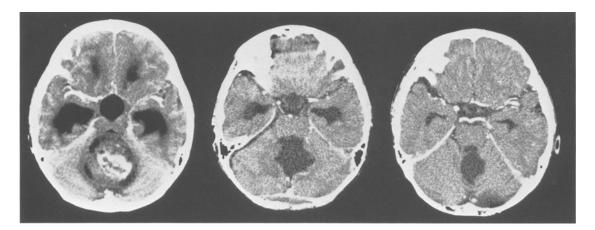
6-year-old girl with progressive headache and ataxia. Left: The pre-operative CT-scan shows a well delineated tumour with inhomogenous and weak contrast enhancement in the vermis and the 4th ventricle (max. diameter: 5 cm); multiple small cysts can be detected in the center and the rim of the tumour. There is also a hydrocephalic dilatation of the lateral ventricles and the 3rd ventricle. Middle: Two days after resection of the tumour a slight enhancement is visible along the left dorsal wall of the dilated 4th ventricle. Right: 6 months later there is no suspicious contrast enhancement, indicating complete resection of the pilocytic astrocytoma
